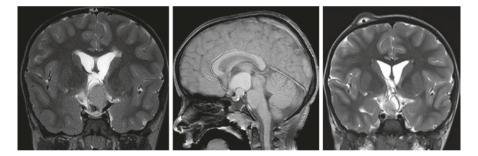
Craniopharyngioma: A coronal T2, sagittal T1 MRI showing a craniopharyngioma in a 6-year-old. The child underwent an endoscopic placement of an ommaya and intracystic catheter, followed by radiotherapy
